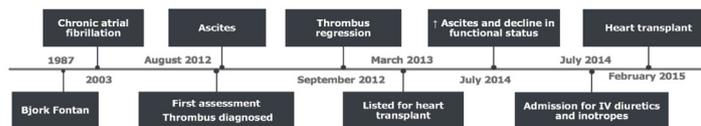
A clinical vignette detailing the complex care pathway of an adult Fontan patient after incidental diagnosis of a large right atrial thrombus. ACHD, adult congenital heart disease; CMR, cardiac magnetic resonance; CT, computed tomography; INR, international normalized ratio; iv, intravenous.
